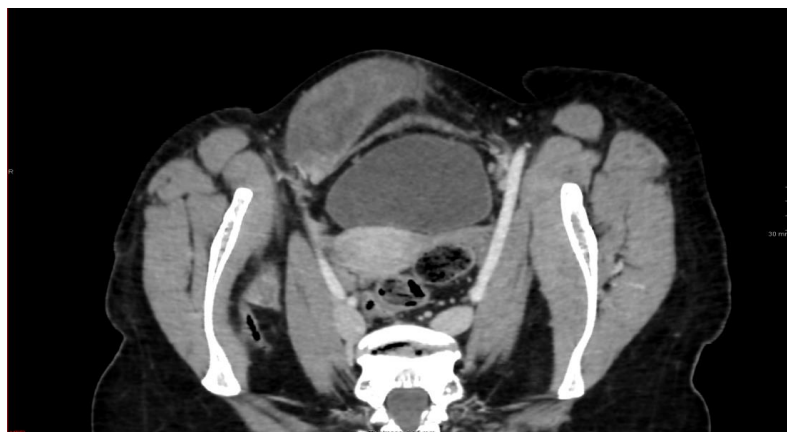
An IV-contrast-enhanced axial CT image shows a sharply defined, hyperdense lesion in the right inguinal region, exhibiting moderate post-contrast enhancement
